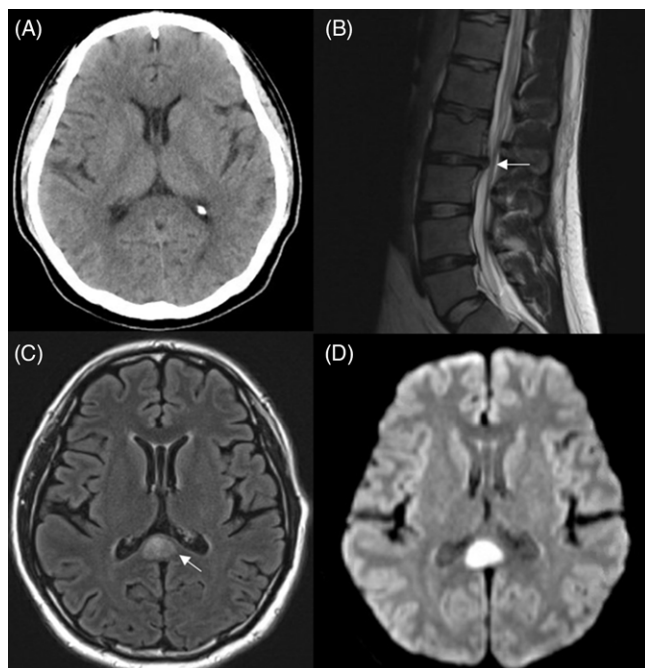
Initial brain CT scan was unremarkable (A). A spinal MRI revealed a mild L4–L5 disc protrusion, with no cord impingement (B). An MRI revealed a T2 hyperintense lesion in the splenium of the corpus callosum (C), which also showed diffusion restriction on DWI (D). No bleeding was observed in the lesion (not shown).
